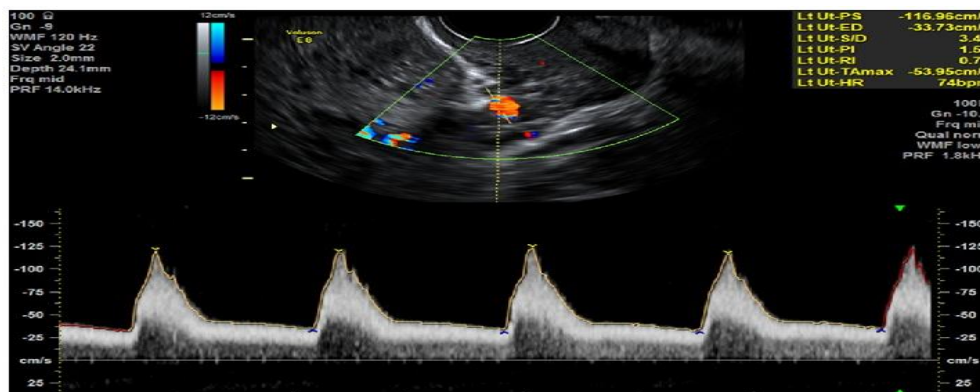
Normal Doppler waveform of the uterine artery
